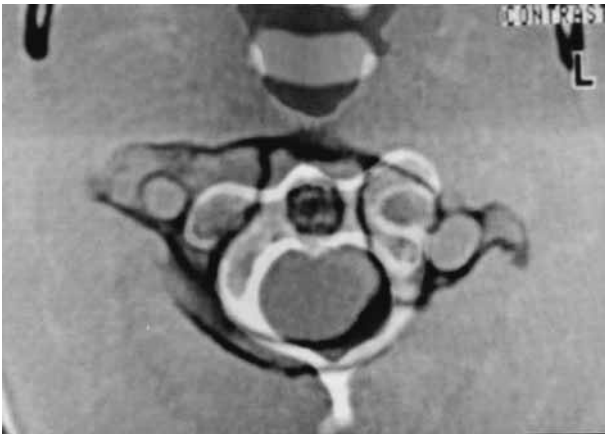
CT scan shows the right lateral mass of C1 lying anteriorly to the articular surface of C2, with normal left C1-C2 joint acting as the pivot of rotation. This is associated with a 4-mm anterior displacement of the anterior arch of C1.
